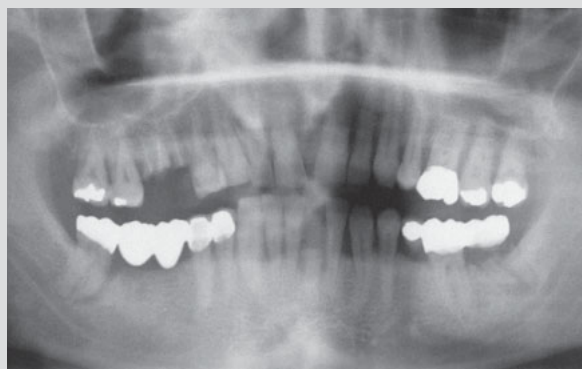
Panoramic radiograph taken for planning purposes.
